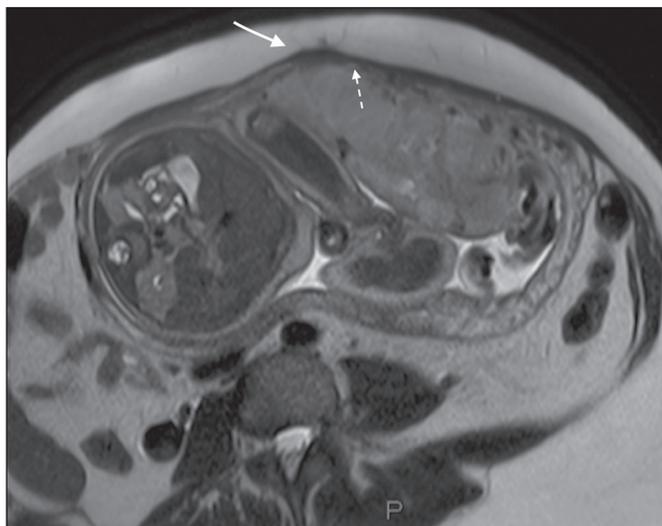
A 36-year-old patient with placenta percreta. Axial T2-weighted HASTE sequence showing abnormal uterine bulging, with a lumpy external uterine contour anteriorly (full arrow), together with myometrial thinning (dashed arrow).
